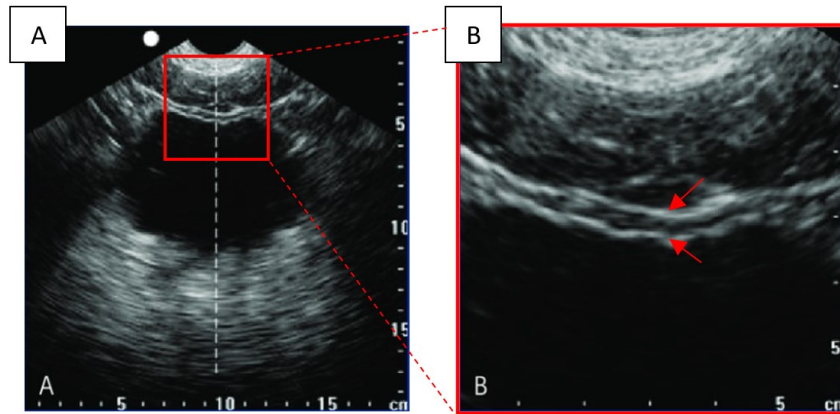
Ultrasound images of a healthy human bladder. A) Transabdominal ultrasound shows a transverse section of the bladder (dark section). The top part of the image depicts the anterior and the bottom part the posterior side. The red square frames the region of figure B. B) Figure A zoomed-in on the anterior bladder wall. The urothelium is not visible since its intensity matches the intensity of the bladder lumen. The two layers with the high intensities indicated by the red arrows are the serosa or adventitia (top red arrow) and the lamina propria (bottom red arrow). The layer with the low intensity in between is the muscularis propria [20].*
